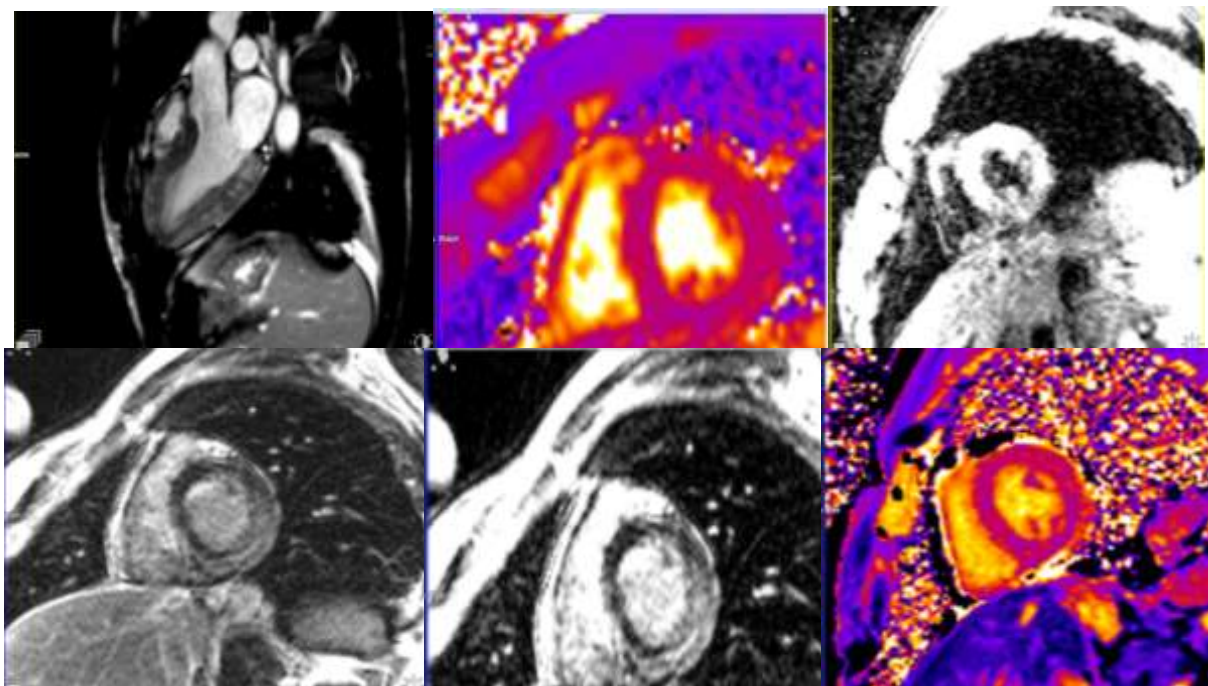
MRI images showing extensive acute myocarditis.
